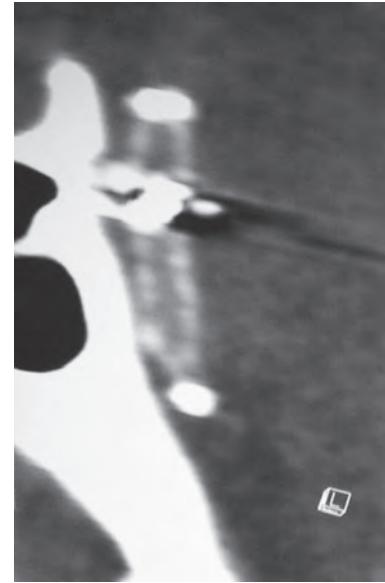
CT head with sagittal three-dimensional reconstruction showing stent in basilar artery (stent-assisted coiling of mid-basilar artery aneurysm)
